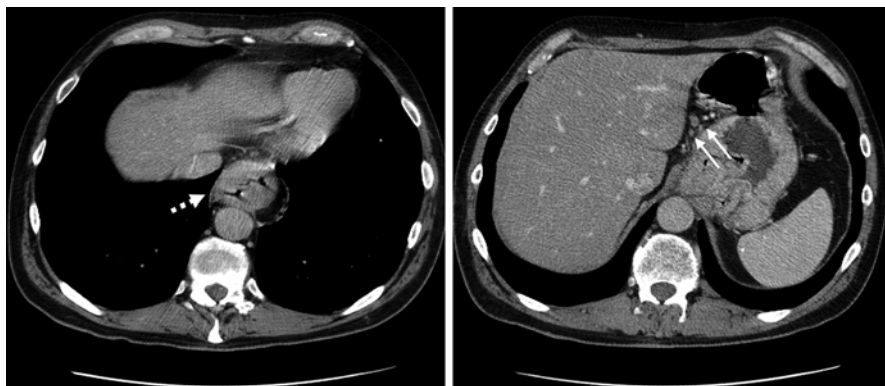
Primary staging of distal esophageal tumor with IV contrast-enhanced CT: axial view of enlarged distal esophageal wall (*dashed arrow*) and enlarged perigastric lymph nodes (*arrows*)
